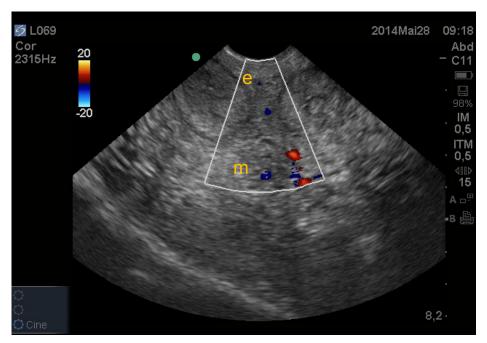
Characterization of a score 1 for the subjective evaluation of the vascularizationpattern of mesometrium 0 by colorimetric evaluation technique in Doppler color mode.
